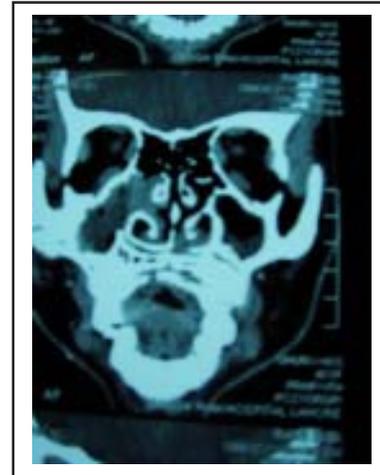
CT of same patient.
